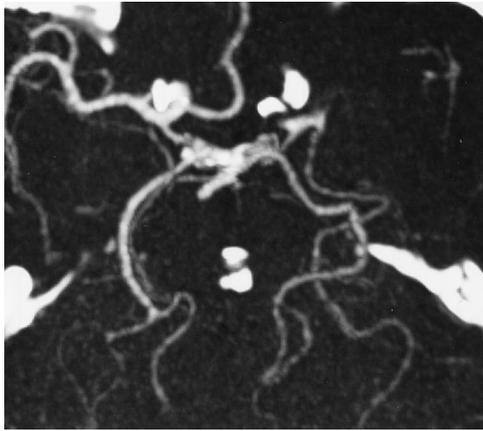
Maximum intensity projection reconstruction of CT angiogram after intravenous bolus injection of 120 mL of contrast material shows a left-sided CTO 210 minutes after onset of right-sided hemiplegia. Note that left C1, M1, and A1 vessel segments are missing, whereas the C2 segment of the ICA is filled by the posterior communicating artery. On the basis of this finding and an anticipated poor prognosis, intraarterial DSA and fibrinolysis were not performed. The patient died 3 days later.
